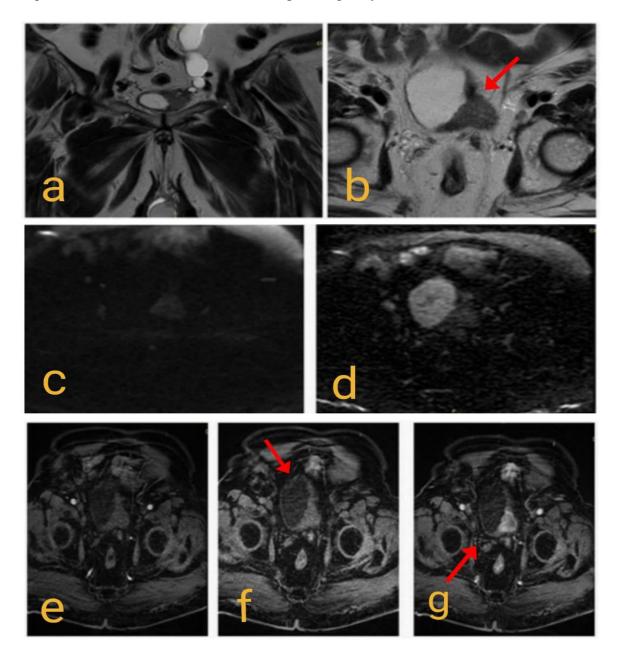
A 65-year-old male patient with a history of recurrent hematuria. Coronal (a) and axial (b) T2WI images shows muscle-invasive left posterolateral UB endophytic mass lesion involving the left vesicoureteric junction with subsequent left-sided moderate hydronephrosis, the mass seen interrupted the underlying detrusor muscle of low signal intensity, without perivesical fat extension (arrows). DWI (c) and ADC map image (d) show highly diffusion restricted of mass with diffusion facilitation of muscle layer exclude muscle invasion and low ADC value about $0.7 \times 10-3$ s/mm2 pointing to malignant nature, DCE-MRI (e) non-contrast subtracted image and (f and g) early arterial phase image are showing
